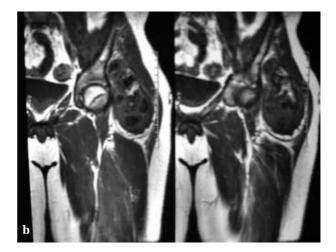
3-dimensional CT (a) and MRI (b) showing the extraskeletal origin of the lesion
